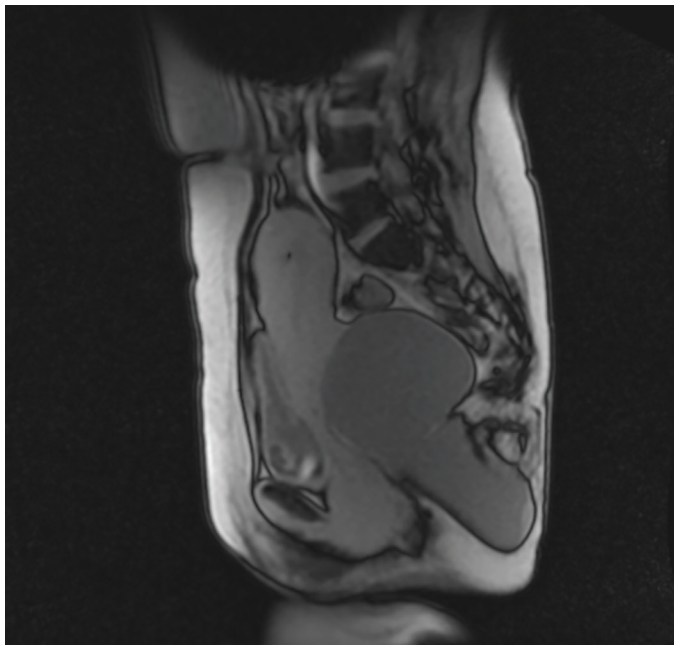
Sagittal pelvic MRI showing a well-defined cystic mass in the rectovaginal space with anterior displacement of the uterus
